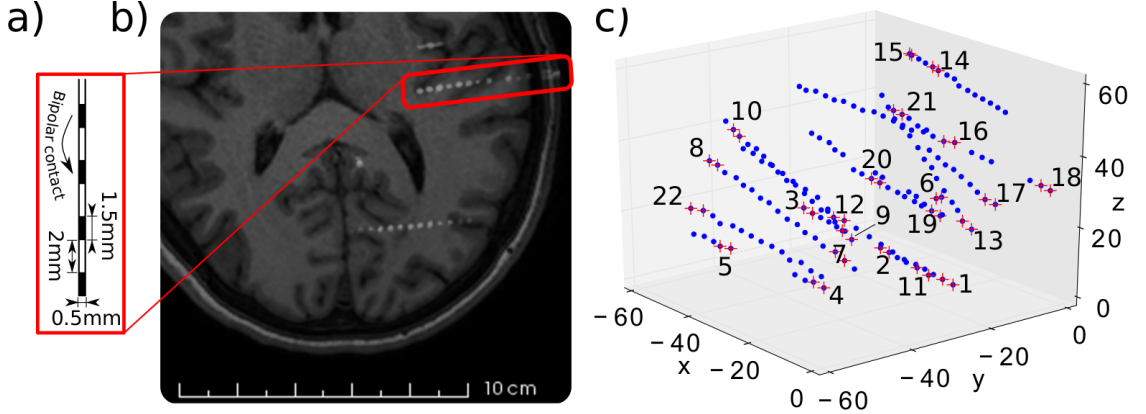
Depth electrode dimensions, location and channel definition. a) Outline of a multi-lead intracerebral electrode. b) Horizontal section of CT scan of subject 1, showing a multi-lead intracerebral electrode (red rectangle) [9]. c) In MNI space in mm, the location of initial contacts (blue dots) are partially overlaid by red crosses, marking the contacts chosen for bipolar-montage. Numbers index the resulting channels as used for analysis. Channels were obtained by applying bipolar-referencing to neighbouring contact pairs that were not discarded (see text for details).
